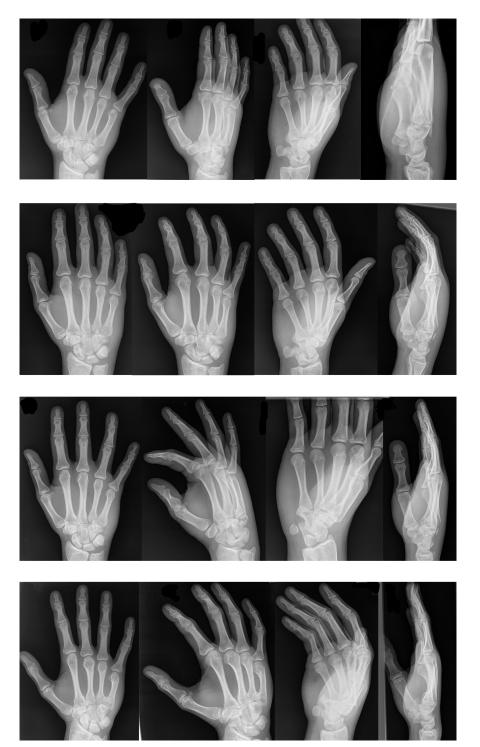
The four fracture-dislocation radiograph sets used throughout the study demonstrating the fracture-dislocation with a bony injury to the hamate.
